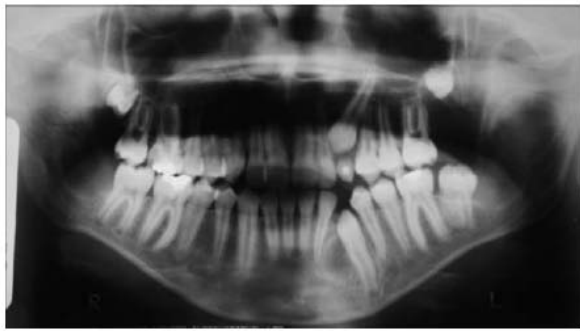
Orthopantomographic examination profile at three months follow-up after the surgery to remove the cystic lesions.
